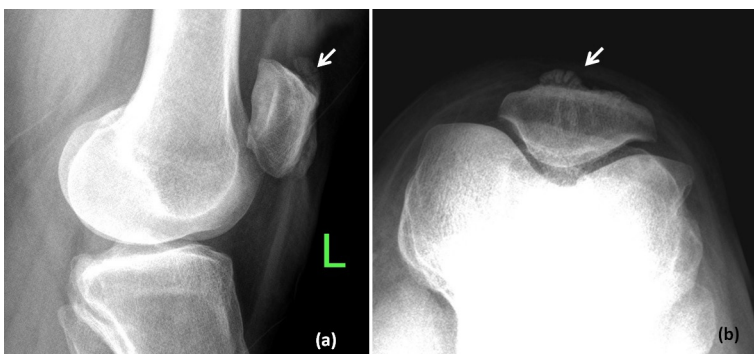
Lateral (a) and skyline (b) radiographs of the left knee in a 64-year-old male patient are shown. The enthesophyte at the upper pole of the patella (arrow in a) creates the "tooth" sign in the skyline view (arrow in b).
